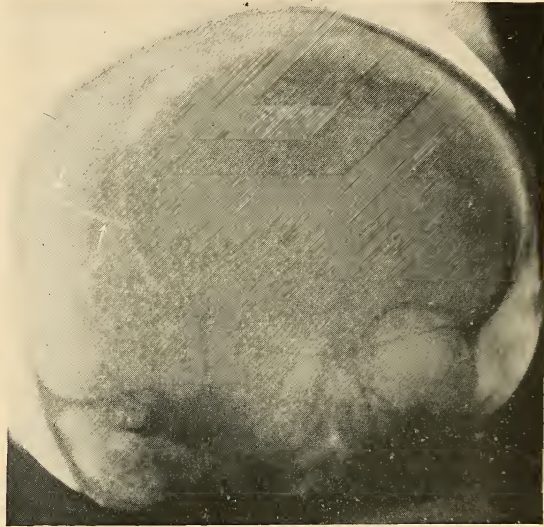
Extensive linear fracture of right parietal bone concealed by an overlying hematoma in a patient who made an excellent recovery with the expectant palliative treatment and the drainage of the hematoma. The importance of roentgenograms of all patients having head injuries is obvious for fear of later complications.
